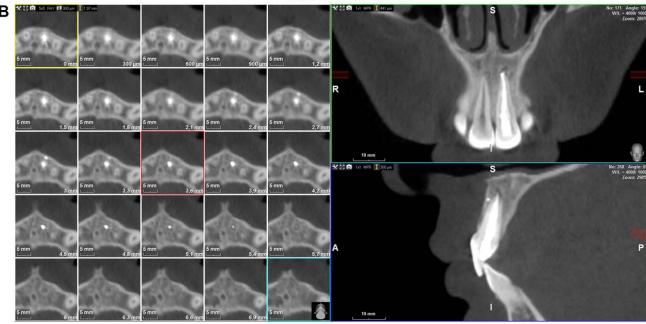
(A) 1-year follow-up intraoral radiograph. (B) 1-year follow-up CBCT sagittal, axial and coronal cross-sections
